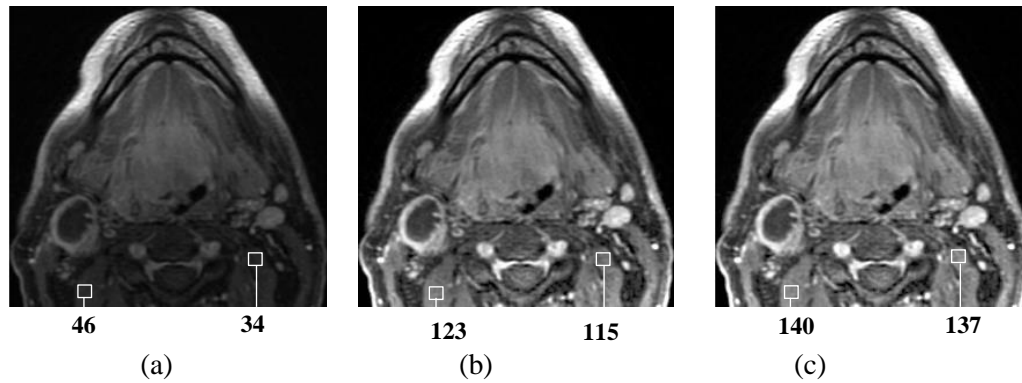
(a) Original MRI slice (b) corrected slice with spline distance 21mm (c) corrected slice with spline distance 16mm (determined using technique described in Section 6.2.) Average intensity values of selected ROIs (white box) are indicated below each slice.
